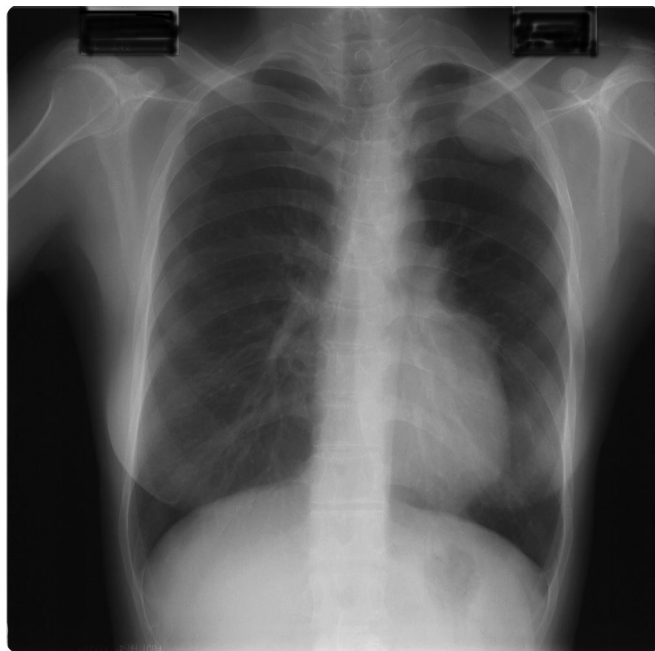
Posteroanterior chest radiograph demonstrating homogenous tumor close to deformed third rib of left chest wall.
